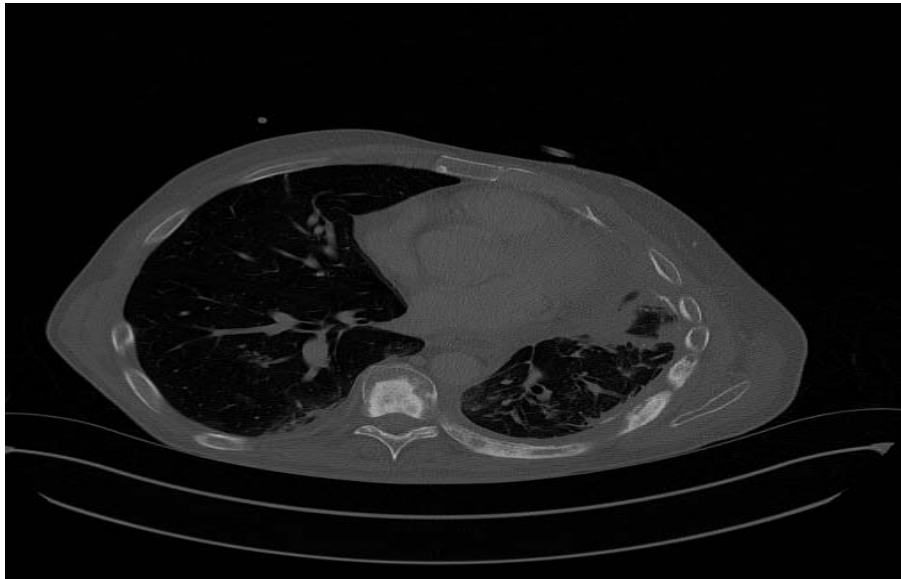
CT scan showed bones metastases
